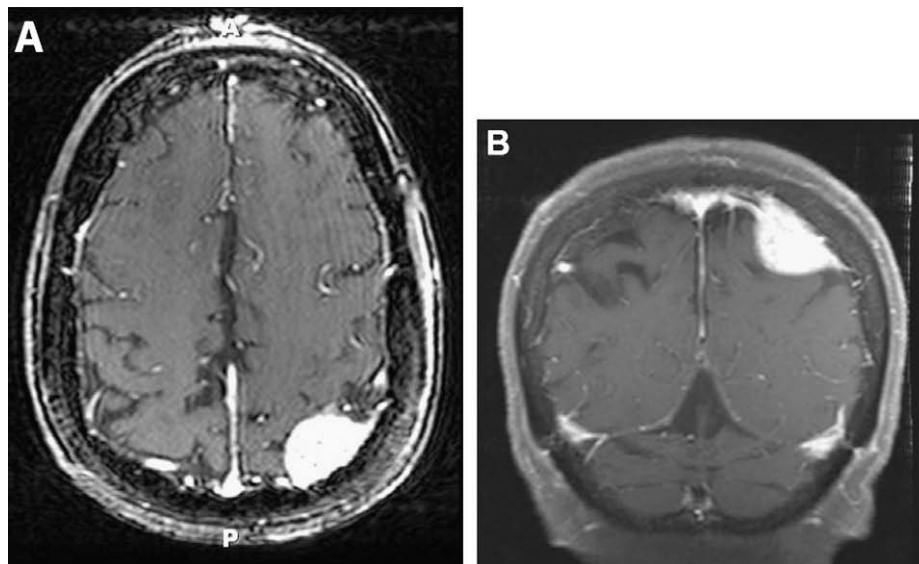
Preoperative (A) axial and (B) coronal T1-weighted MRI with contrast enhancement showing the left parieto-occipital convexity meningioma.
